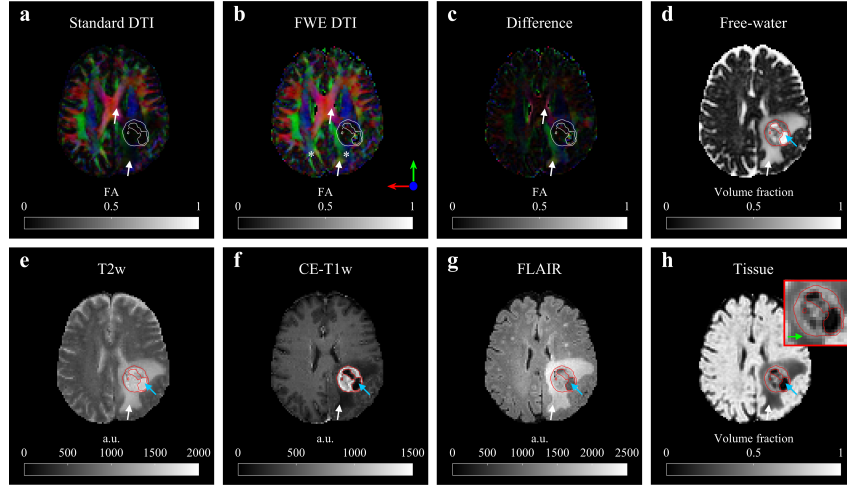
Comparison of metrics and contrasts for one patient. Fractional anisotropy from standard DTI (a) showed a dimmed region corresponding to edema (white arrows). This area was recovered after free-water elimination (b and c). We observed alterations of the white matter integrity compared to the NAWM (b, white asterisks). Free-water (d) and tissue (h) volume fraction maps were estimated by the ANN. Edema regions were well defined and distinguishable from the tumor (red contour). Pools compatible with cytotoxic edema were observable inside the tumor (light-blue arrows). These findings agreed with the observations based on T2w (e), CE-T1w (f), and FLAIR (g). Extended tumor infiltration was derived from the comparison of CE-T1w and tissue volume fraction map (h, gree arrow).
